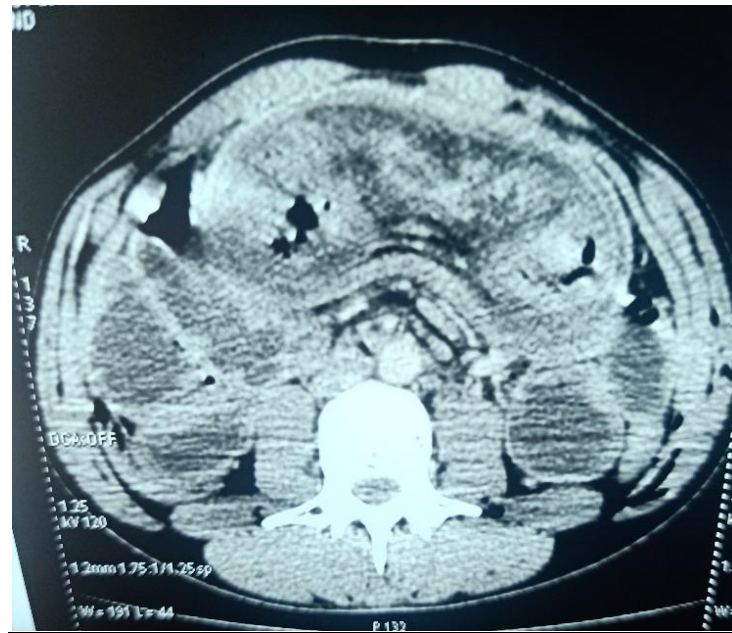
Axial CT of the abdomen shows the presence of a bowel-within-bowel, characteristic for intussusception
